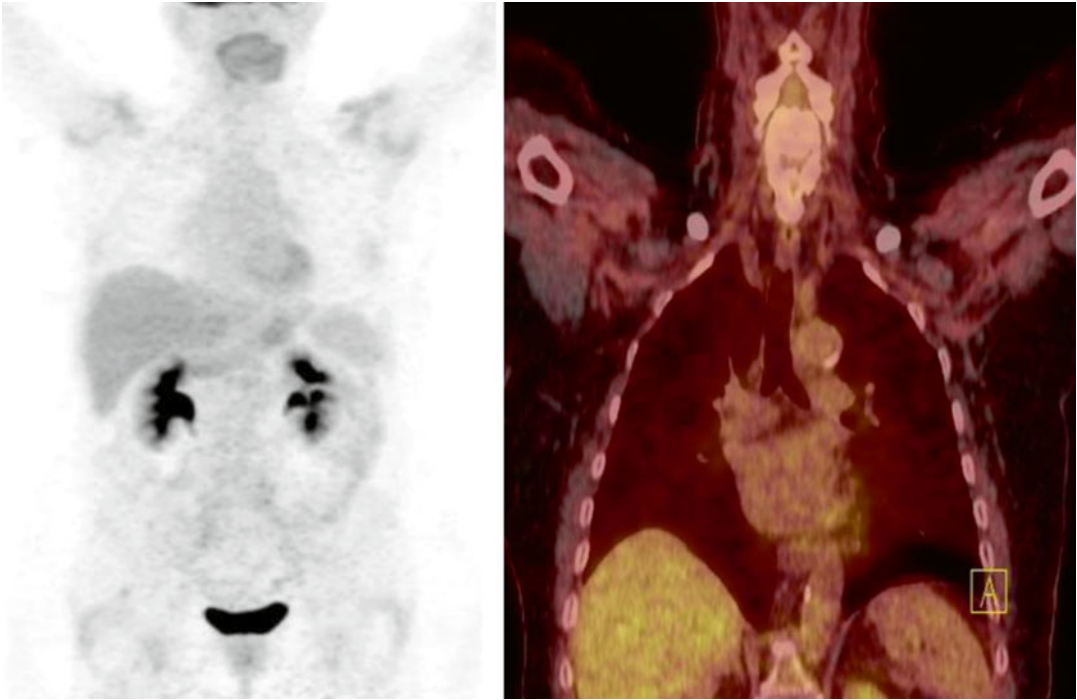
MIP-PET and fused PET/CT images: No lesions of increased uptake of the radiopharmaceutical are observed
